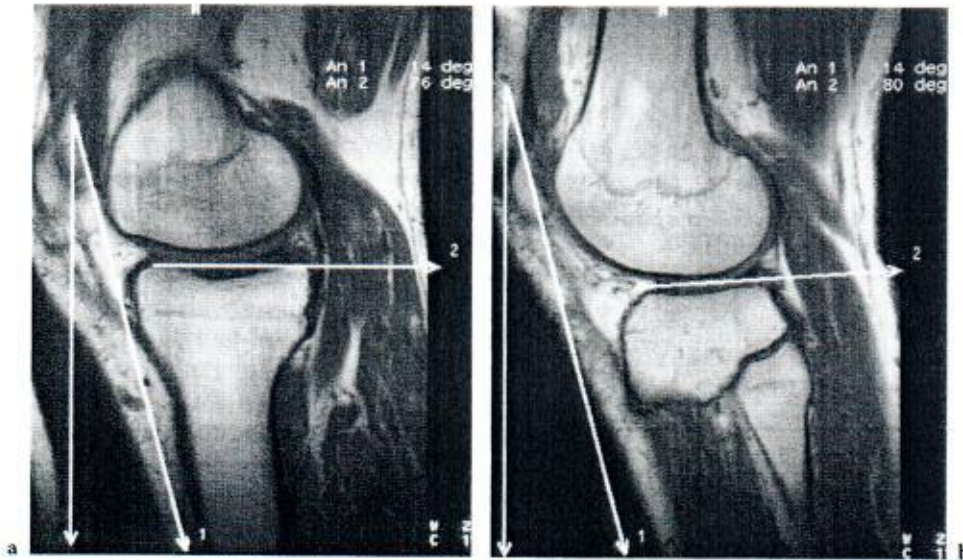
Sagittal T1-weighted MR images of the medial and lateral femoral and tibial condyles. The oblique line (1) is in a different image joining the anterior crest of the tibia. Relative to vertical (horizontal) the inclination of the tibia is 14°. The concave contour of the medial tibial condyles (a) is horizontal and thus has a dorsal slope of 14°. The orientation of the straight (commonly convex) contour of the lateral tibial condyle (b) is 4° less than that of the medial tibial condyle
